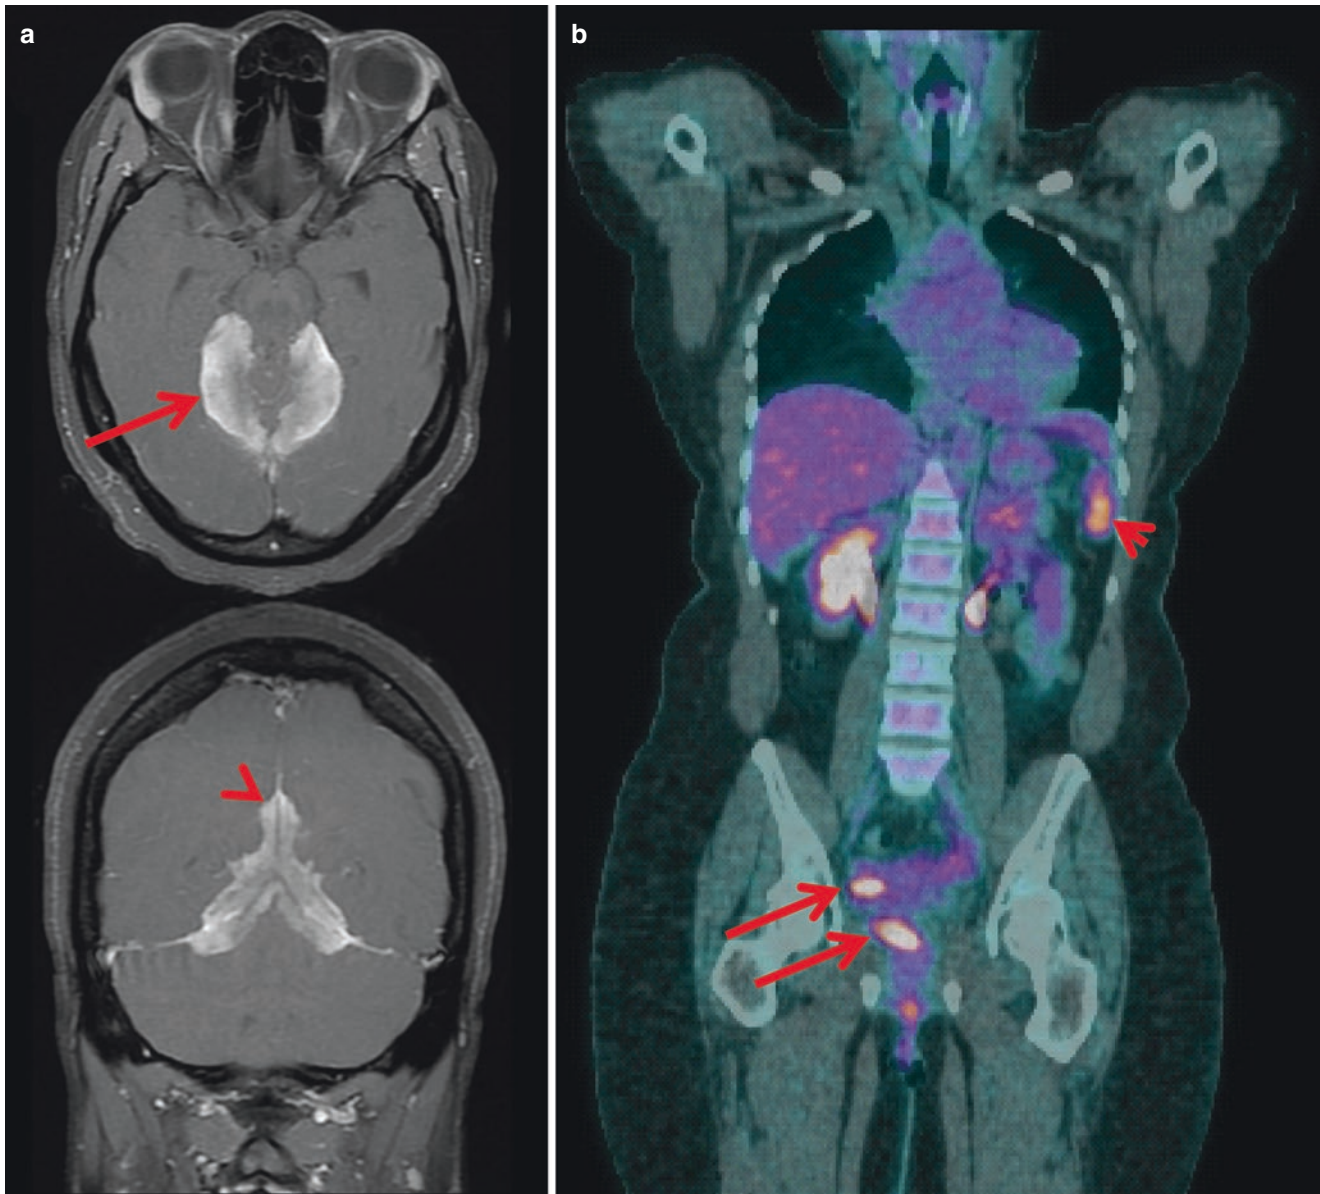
A 39-year-old woman presented with new headaches. (a) T1-weighted postcontrast brain magnetic resonance imaging (MRI) demonstrated thickening and contrast enhancement of the falx cerebri (arrowhead) and tentorium cerebelli (arrow). (b) Positron emission tomography (PET) scan demonstrated multiple fluorodeoxyglucose (FDG) avid splenic lesions (arrowhead) and several avid femoral and deep iliac lymph nodes. Lymph node biopsy demonstrated multiple
